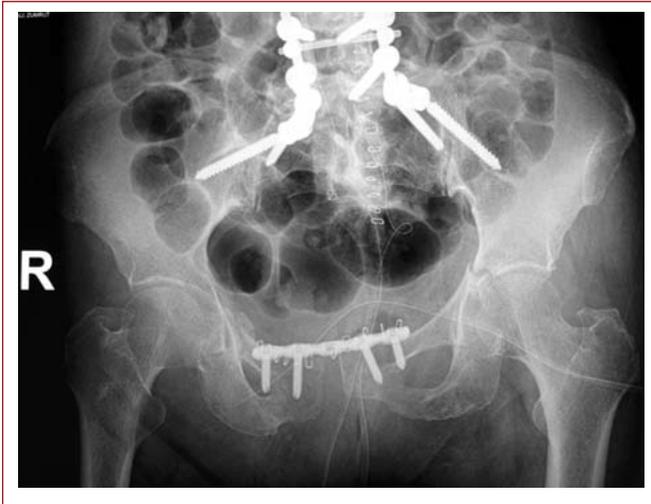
Postoperative AP X-ray
